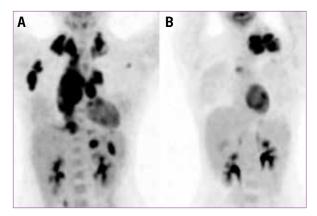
Staging ¹⁸F-fluorodeoxyglucose–positron emission tomography/computed tomography image of 2 patients with early stage unfavorable (intermediate-risk) Hodgkin lymphoma. A is from a young woman with bulky stage IIA Hodgkin lymphoma, and B is from a man with stage IIB Hodgkin lymphoma and peripheral bulk. The risks associated with radiotherapy are substantially different for these patients, despite their being in the same prognostic category.
